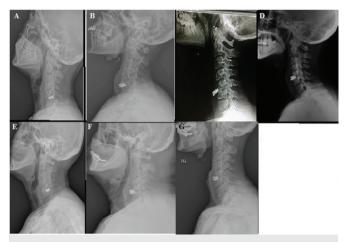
(A-G) Lateral cervical radiographic examination of patients
